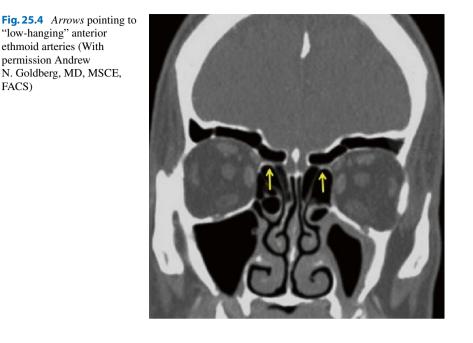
Coronal CT, *arrows* pointing to anterior ethmoid arteries (With permission Andrew N. Goldberg, MD, MSCE, FACS)
